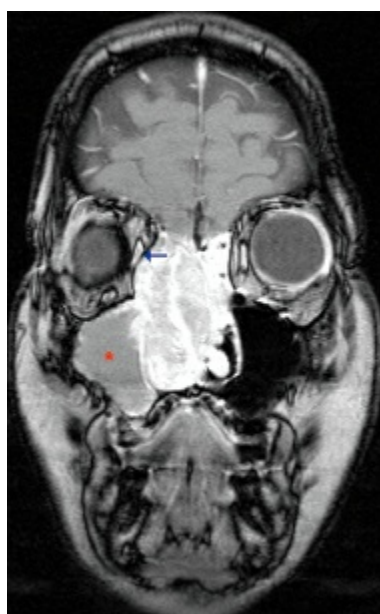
Postcontrast T1 coronal image of a sinonasal mucosal melanoma. MRI allows for the distinction between the vascular tumor and trapped secretions in the maxillary sinus (*asterisk*), and provides evidence that the periorbita is intact (*arrow*).
